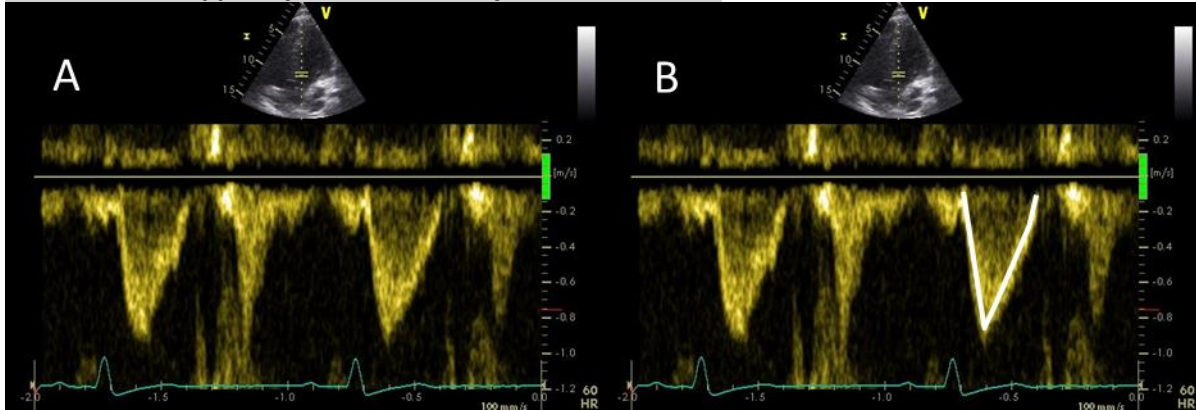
PW Doppler LVOT (A) and measurement PW Doppler LVOT (B)
